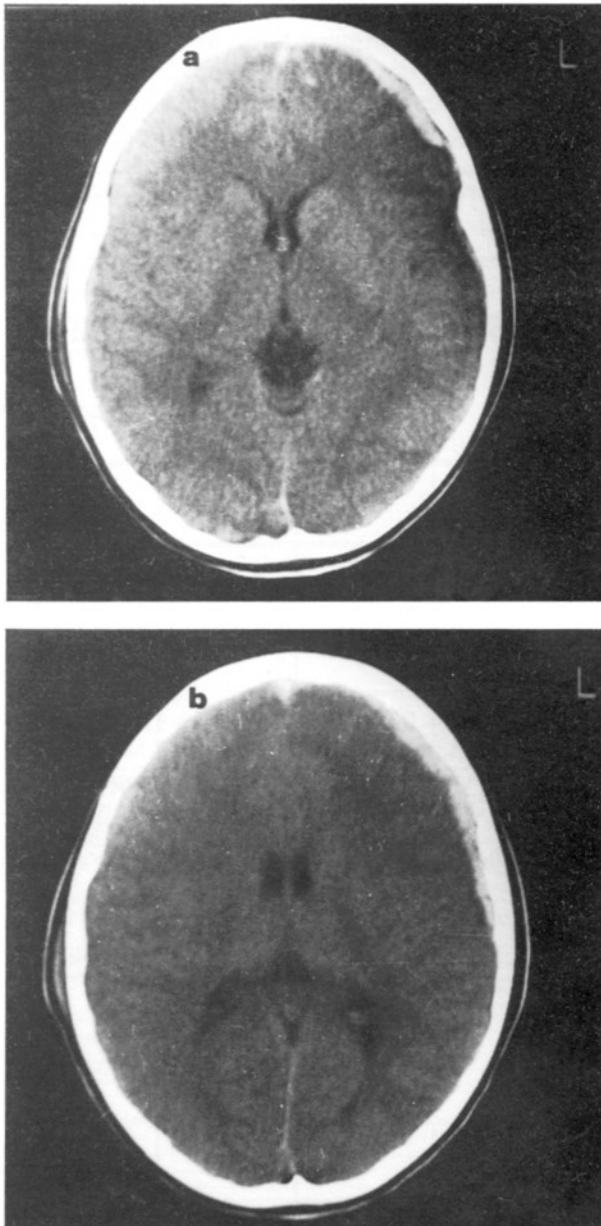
a and b. CT-scan two hours after trauma showing left frontoparietal acute subdural hematoma. Ventricles are compressed due to cerebral swelling. Note the small contusion in the left frontal lobe.
